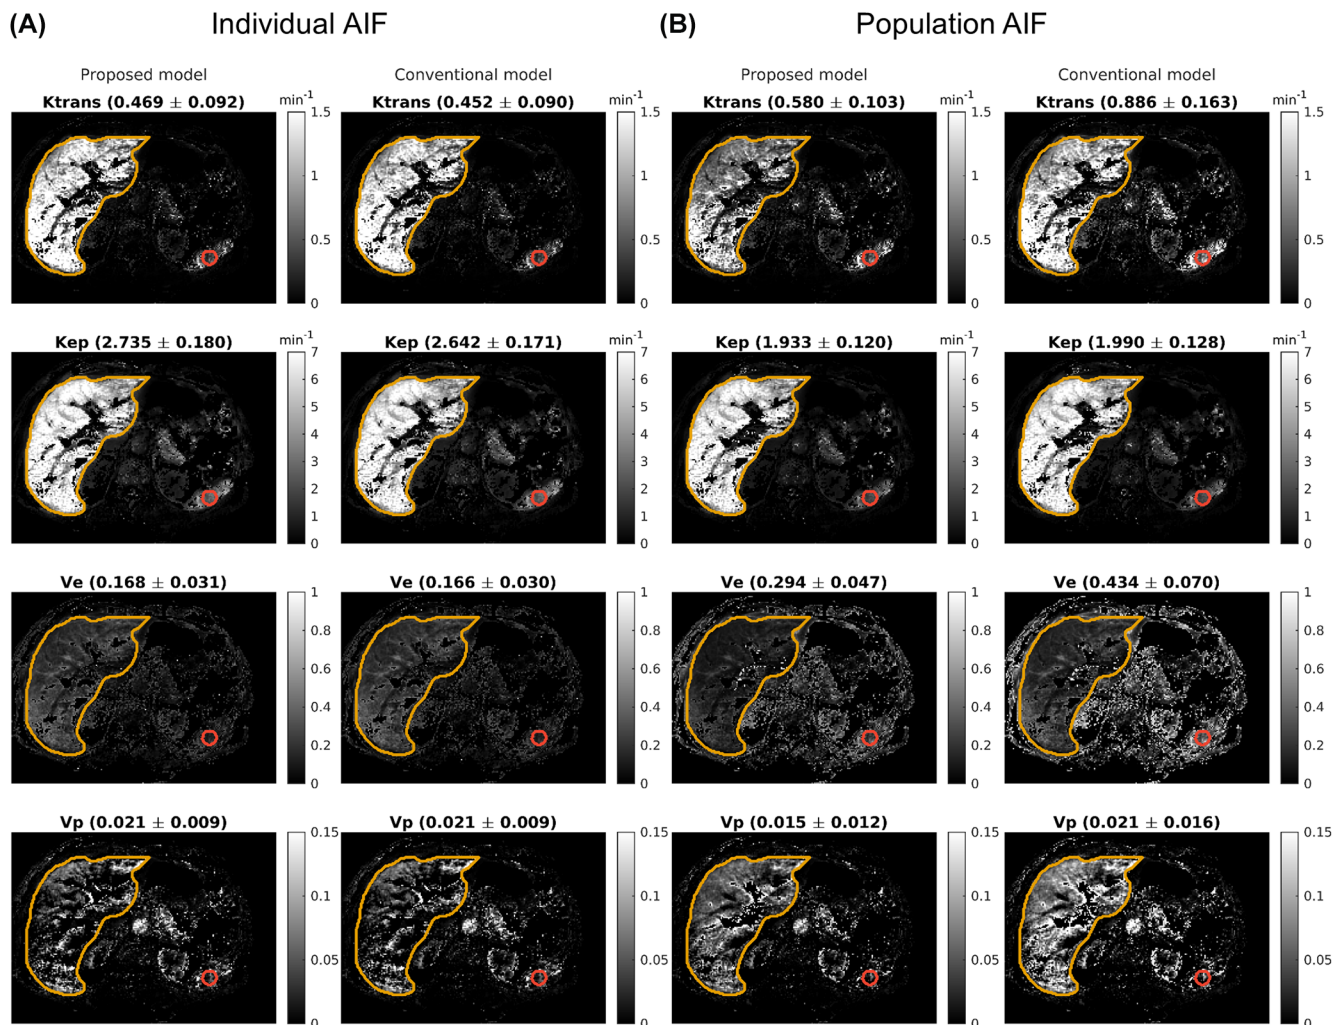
Parameters of DCE MRI in the abdomen of a healthy volunteer, with A the results when an individualized AIF is used and B with a population-based AIF. In both cases, the left column represents the parameter maps when using the proposed model and the right column displays the results with the conventional model. The mean and standard deviation within a region of interest in the spleen (circled in red) are presented in the title of the images. Furthermore, the mask of the liver where the dual inlet model was used is drawn in yellow.
